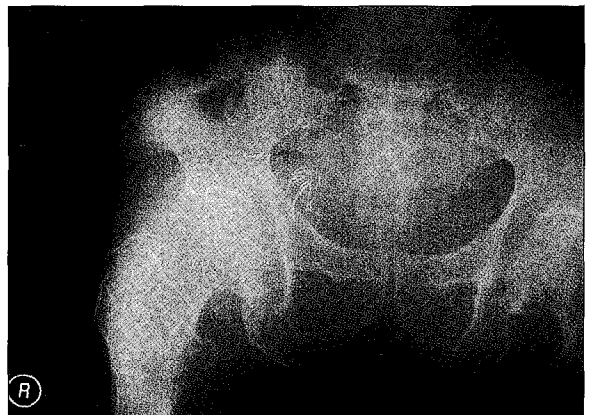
Pre-operative radiograph of the pelvis shows a radiolucent material in the pelvic cavity
